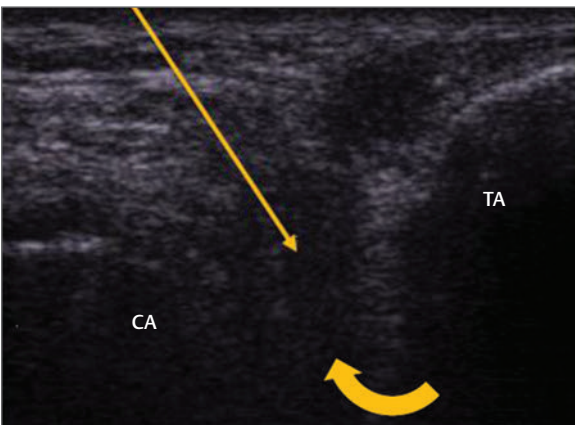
Ultrasound image of the anterolateral opening of the sinus tarsi. The talus (TA) forms the roof of the sinus tarsi and the calcaneum (CA) the floor. The anterolateral opening of the sinus tarsi is shown by the curved arrow. The straight arrow demonstrates the direction of the needle.
